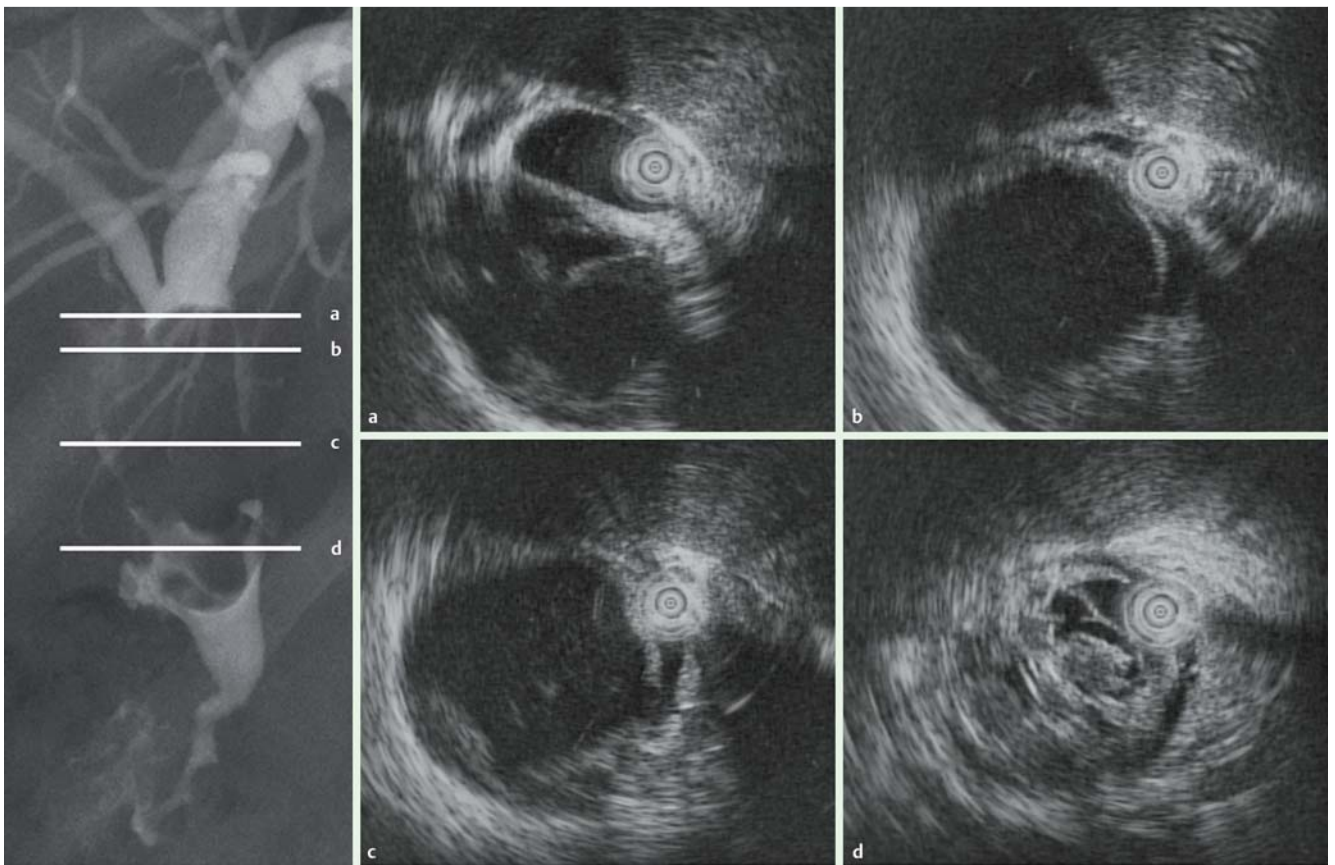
Intraductal ultrasonography: the multilocular lesion gradually compressed the wall of the common bile duct and finally occluded the lumen.
